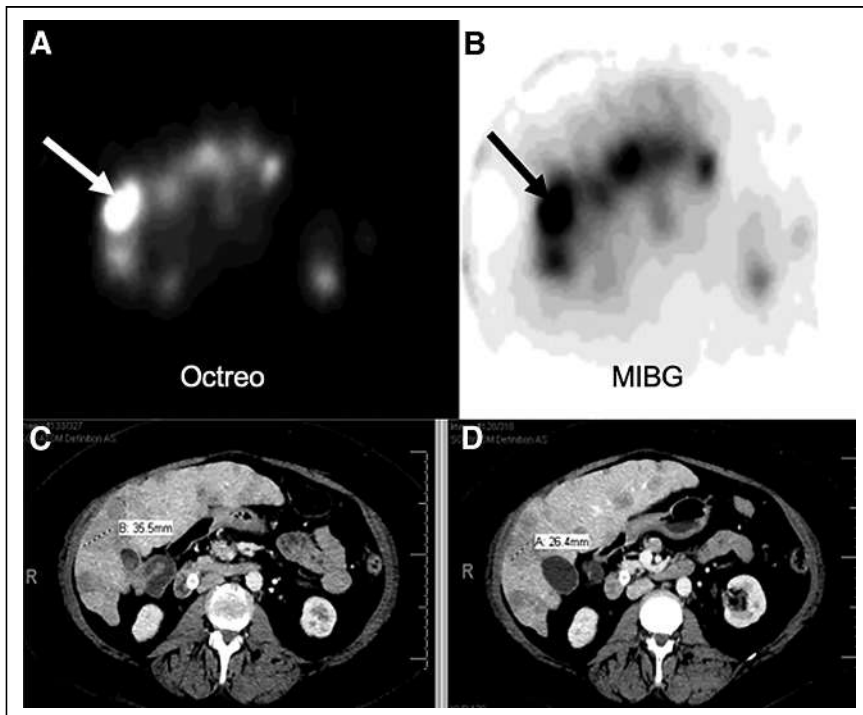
Subject 1. (A) ^{111}In -pentetreotide axial SPECT image through mid liver demonstrating multiple octreotide-positive metastases with focal intense uptake in target lesion (arrow). (B) ^{131}I -MIBG SPECT axial slice at same level demonstrating intense uptake in same lesion (arrow). (C) Corresponding baseline venous phase CT scan depicting multiple liver metastases consistent with SPECT findings. Target lesion is 35.5 mm in maximum diameter. (D) Follow-up CT 6-mo after cycle 2 showing measurement of target lesion (maximum diameter, 26.4 mm).
